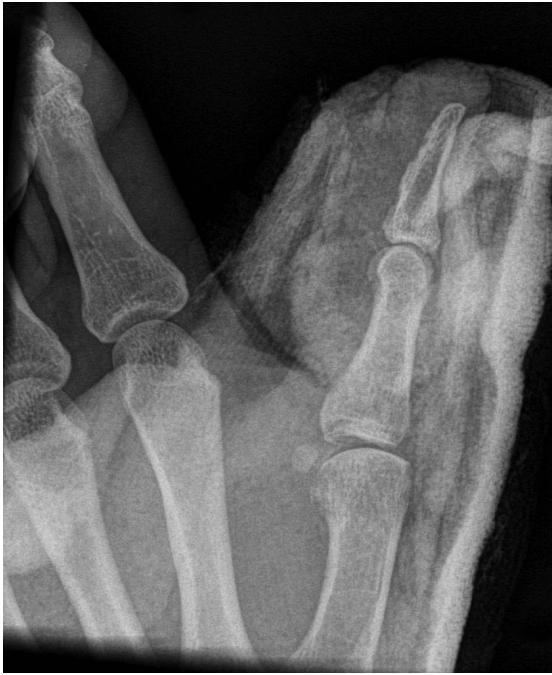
Post-reduction radiograph shows the anatomical reduction of both joints.
